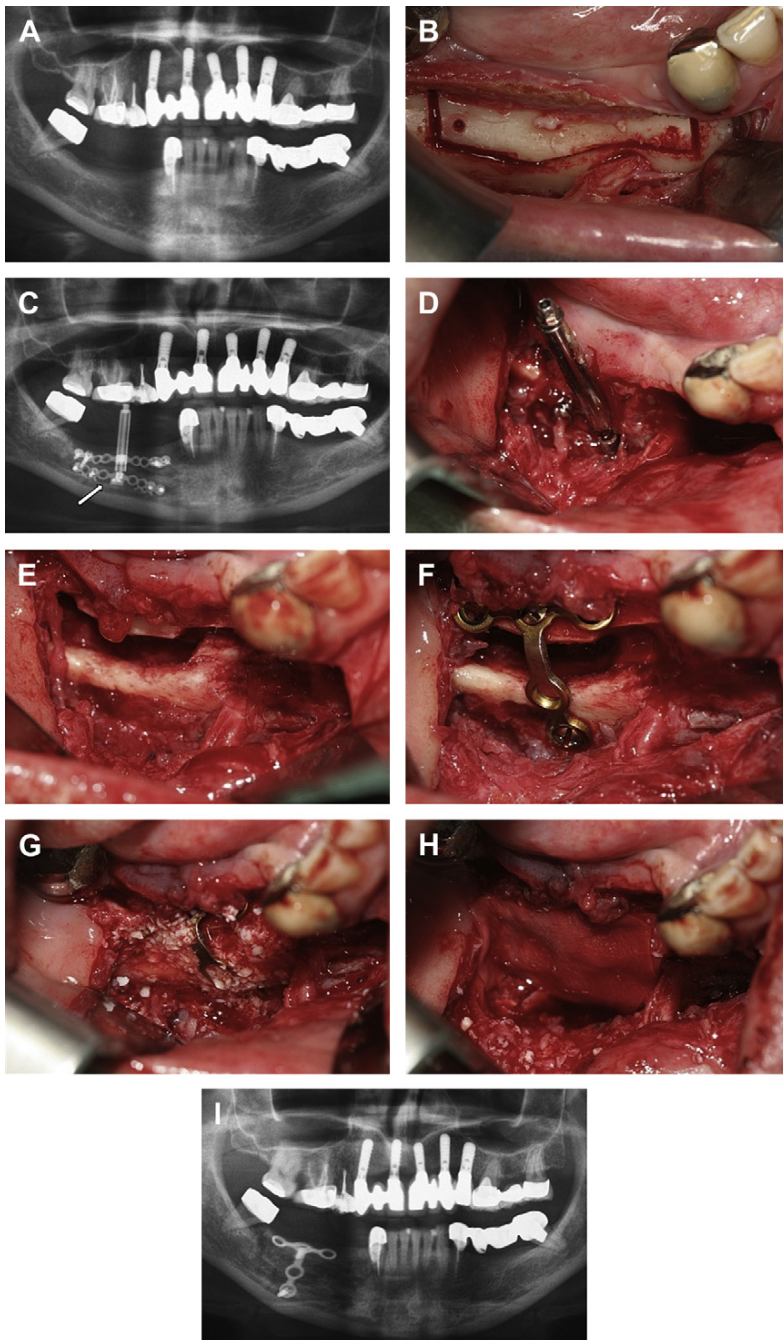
Fracture of alveolar distractor device treated with bone graft procedure. (A) Right mandibular vertical defect. (B) Osteotomy. (C, D) Panoramic radiograph and clinical picture showing fracture of the alveolar distraction device. (E) Distraction gap after removal of device. (F) Stabilization of transport segment with miniplates. (G, H) Bone graft and membrane in place. (I) Radiograph showing vertical bone augmentation.
